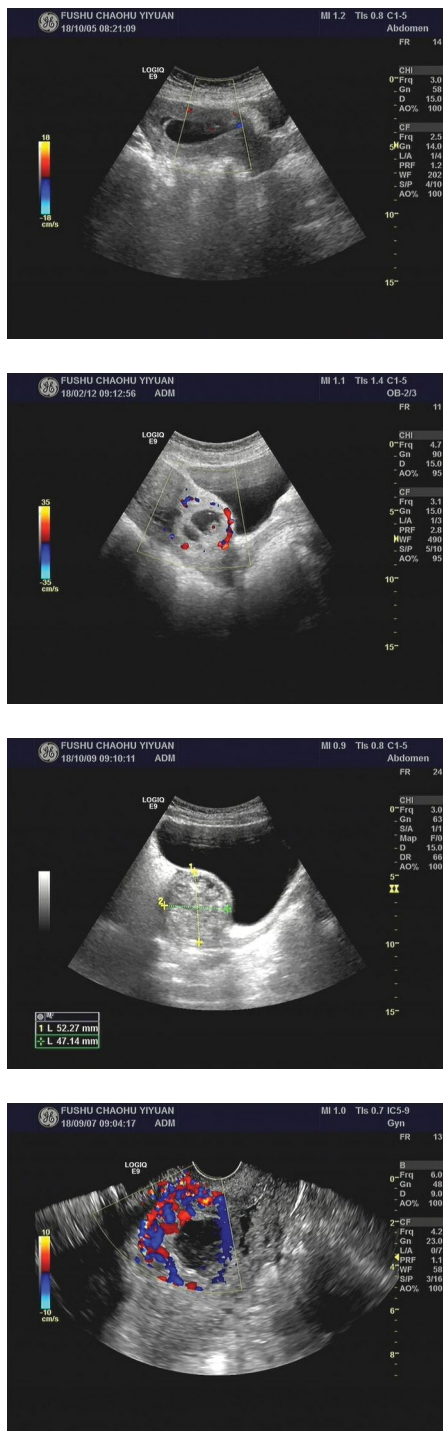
Ultrasound images of the 3 types of CSP. A, partial type. B, complete type. C and D, mass type
